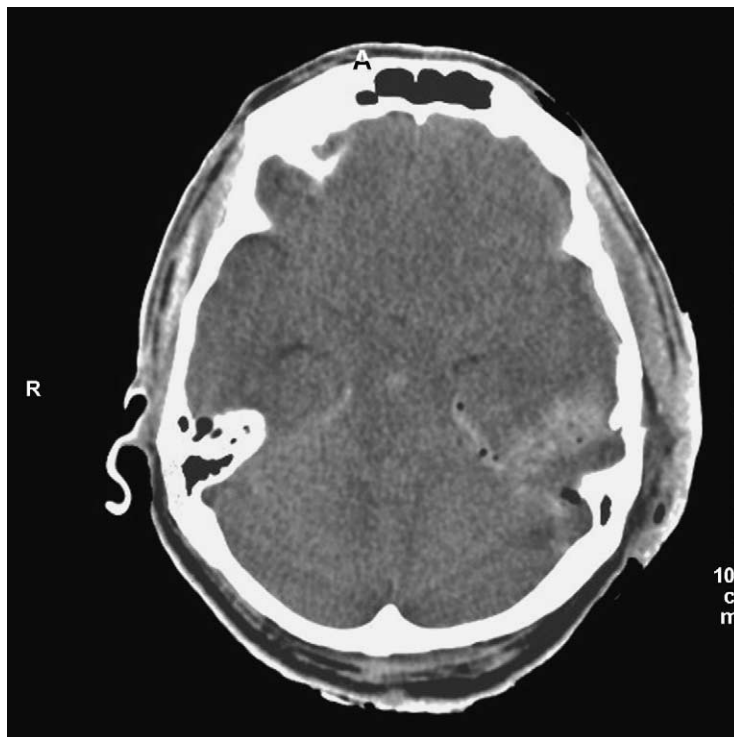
Non-contrasted CT scan showing hemorrhagic wound tract in the left temporal lobe with air inclusions and diffuse brain swelling.
